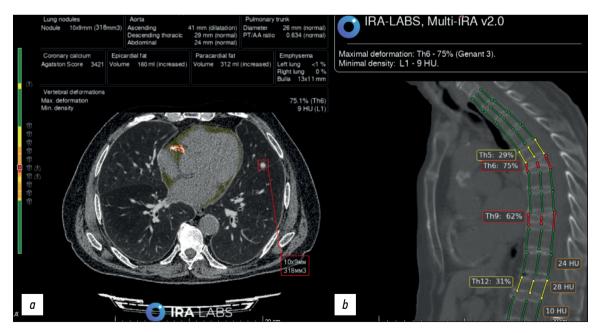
An example of AI use. Patient B., 79 years old. Chest CT scans: *a*) axial section: a radiologist and an algorithm correctly identified a lung nodule in the left lung (indicated by a red square) and coronary calcification (outlined by an orange line). In addition, the algorithm indicated an increase in the volume of epicardial fat (filled in yellow; this pathological finding was not considered in the study); *b*) sagittal section: a radiologist and an algorithm correctly identified compression fractures of Th6 and Th9 vertebral bodies, Genant 3 (three columns are marked with red lines); however, the radiologist did not indicate deformities of Th5 and Th12 vertebral bodies, Genant 2 (three columns are marked with yellow lines) in the protocol.
